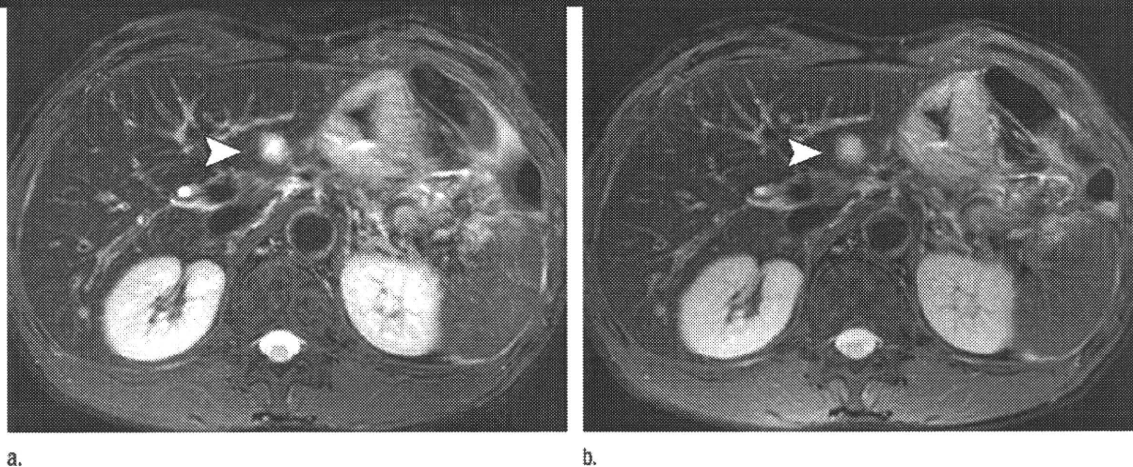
Fat-saturated T2-weighted TSE axial MR images obtained after SPIO administration with respiratory triggering in a 48-year-old woman with hepatocellular carcinoma. (a) Image acquired with the PACE method alone depicts the hepatic tumor (arrowhead) in segment II less clearly than in b because of ghosting artifacts; however, a hepatic cyst in segment IV is apparent. (b) The hepatic tumor (arrowhead) in segment II is clearly visible on the PROPELLER MR image.
